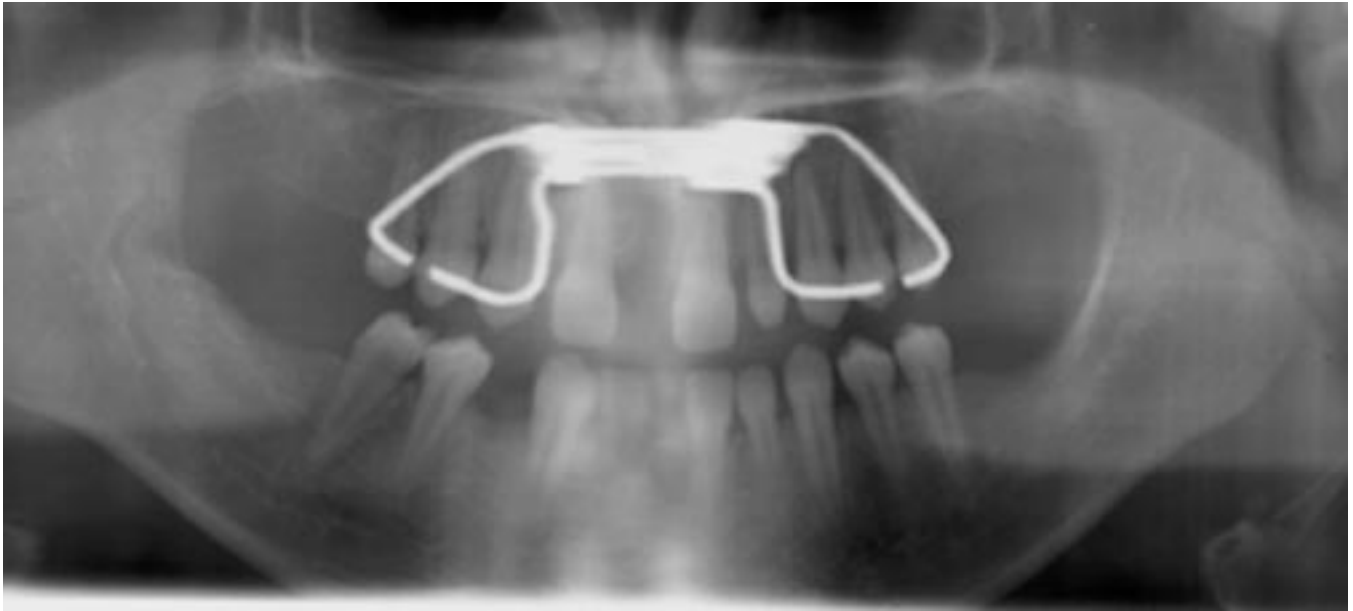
Panoramic radiograph of patient after 20 days of expansion.
